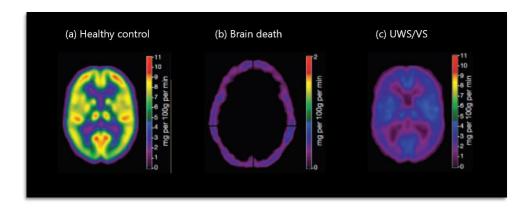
Cerebral resting brain metabolism acquired with <sup>18</sup>Fluorodeoxyglucose – positron emission tomography (FDG-PET) in (a) healthy control, patients with (b) brain death and (c) unresponsive wakefulness syndrome (UWS) or vegetative state (VS). In brain death, we can observe an "empty skull sign" whereas in UWS/VS, the cerebral metabolism is highly and globally decreased but not absent. The color scale shows the amount of glucose metabolized per 100 g of brain tissue per minute. Adapted from (Steven Laureys, 2005)
